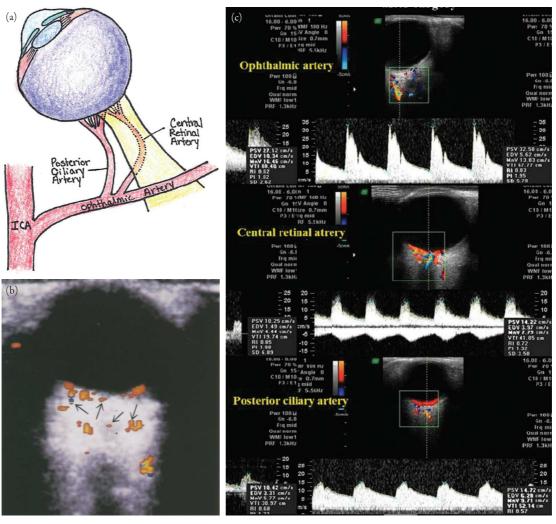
(a) Blood supply to the eye. The ophthalmic artery branches off of the internal carotid artery and further divides into the posterior ciliary artery and central retinal artery. (b) The color Doppler image is provided for a patient with central retinal artery occlusion on whom no flow was detectable within the optic nerve. Posterior ciliary arteries are still detectable (arrows). Adapted from Figure 8 of Williamson TH, Harris A. Color Doppler ultrasound imaging of the eye and orbit. Surv Ophthalmol. 1996;40(4):255–267. (c) Doppler patterns of arterial supply to the eye. the ophthalmic artery has a similar Doppler pattern to the internal carotid artery with a dicrotic notch with sharp peaks. The central retinal artery is located closer to the retina within the distal optic nerve and has a Doppler pattern consistent with rounded peaks. Posterior ciliary arteries are located lateral to the optic nerve near the retina, and also have rounded peak waveforms.
